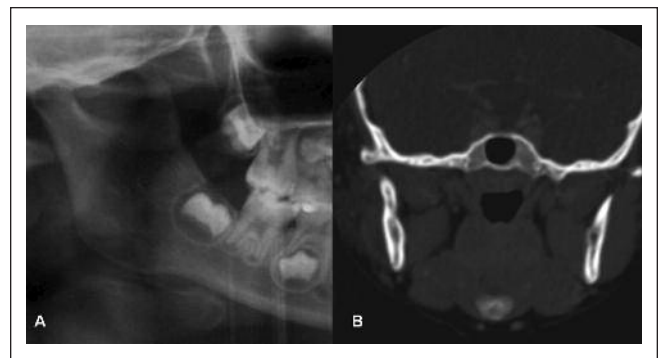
Postoperative panoramic radiography (A) and computed tomography (B) obtained 12 months after chemotherapy.
